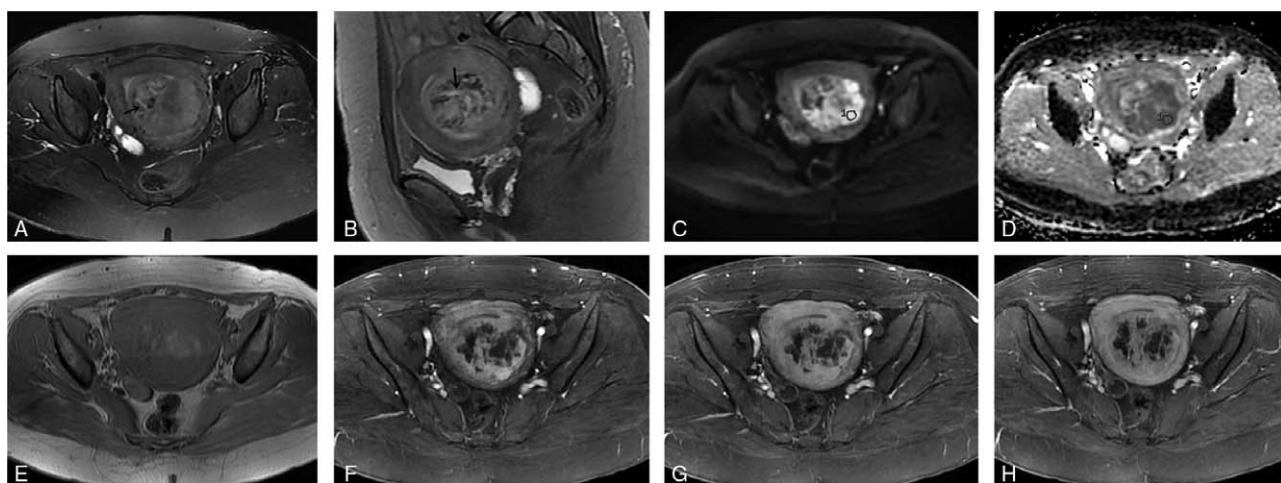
A 50-year-old woman with LMS confirmed by surgery and pathology. (a, b) Axial and sagittal T2-weighted image indicated a mixed-signal mass was major located in the myometrium with slit-like cystic change or necrosis (black arrows). (c) Axial diffusion-weighted imaging showed hyperintensity in the solid component of tumor. (d) Axial ADC map revealed the solid component of LMS showed restricted diffusion, and the mean ADC, minimum ADC, and rADC values were $1.04 \times 10^{-3} \text{mm}^2/\text{s}$, $0.89 \times 10^{-3} \text{mm}^2/\text{s}$, and 0.67, respectively. (e) Axial T1-weighted image appeared hemorrhage (red arrow). (f-h) Axial contrast-enhanced magnetic resonance imaging including arterial phase, venous phase, and delayed phase, and LMS displayed marked enhancement in arterial phase. LMS = uterine leiomyosarcoma, ADC = apparent diffusion coefficient, rADC = lesion-muscle ADC ratio.
